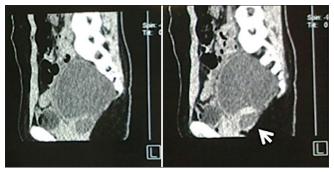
CT metrizamide myelography shows the cyst and its extension to the anorectal region.
